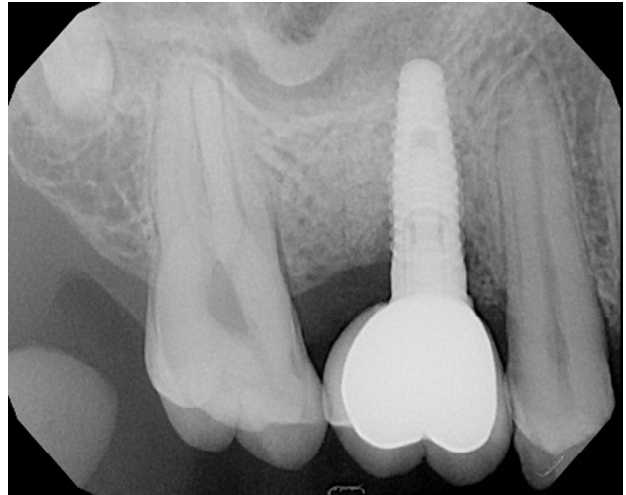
Post prosthetic rehabilitation radiograph
